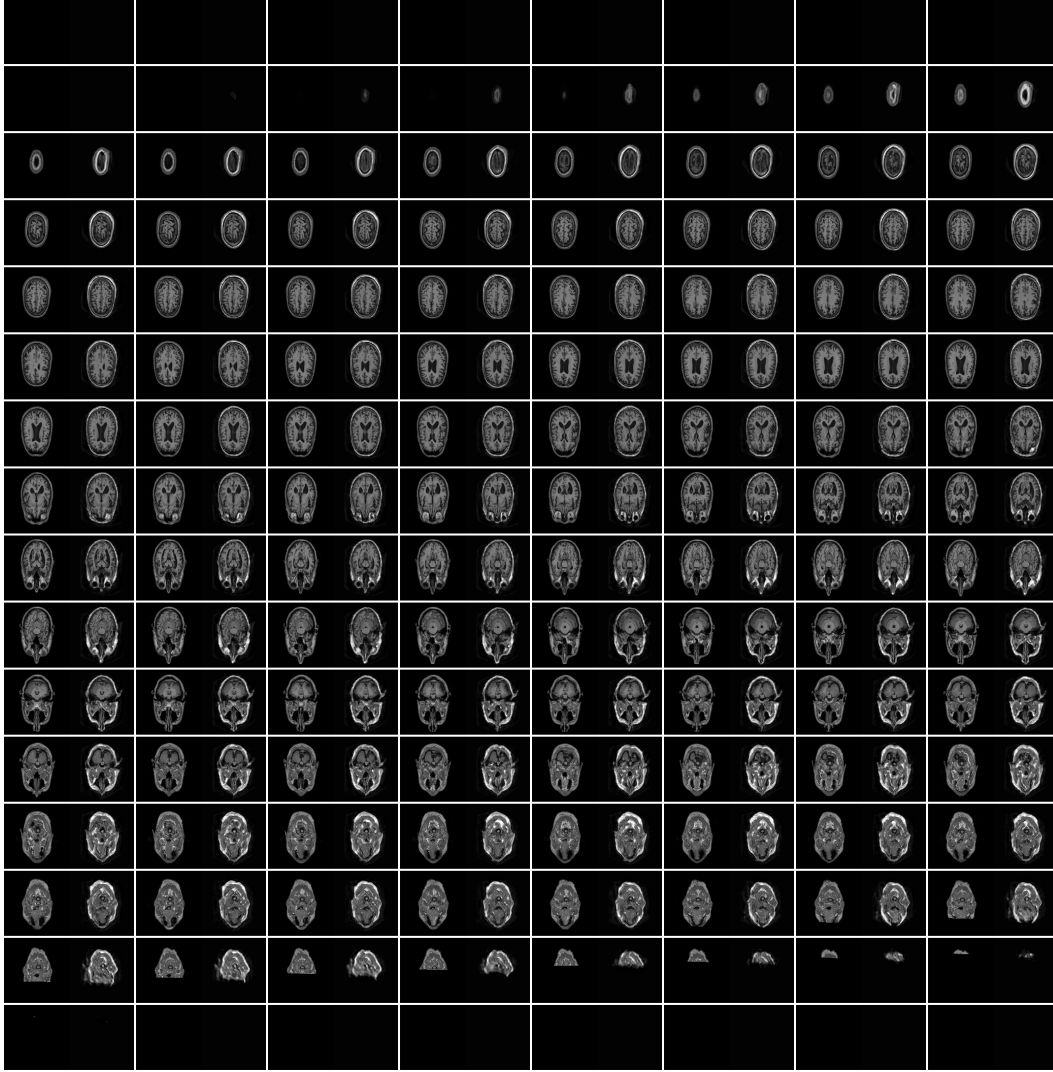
Original MRI slices and those generated from C-DeID-GAN (ADNI): Slices (of a single patient) run from left to right and from top to bottom. Each box corresponds to one slice index and contains the original on the left and the synthesized counterpart on the right.*
